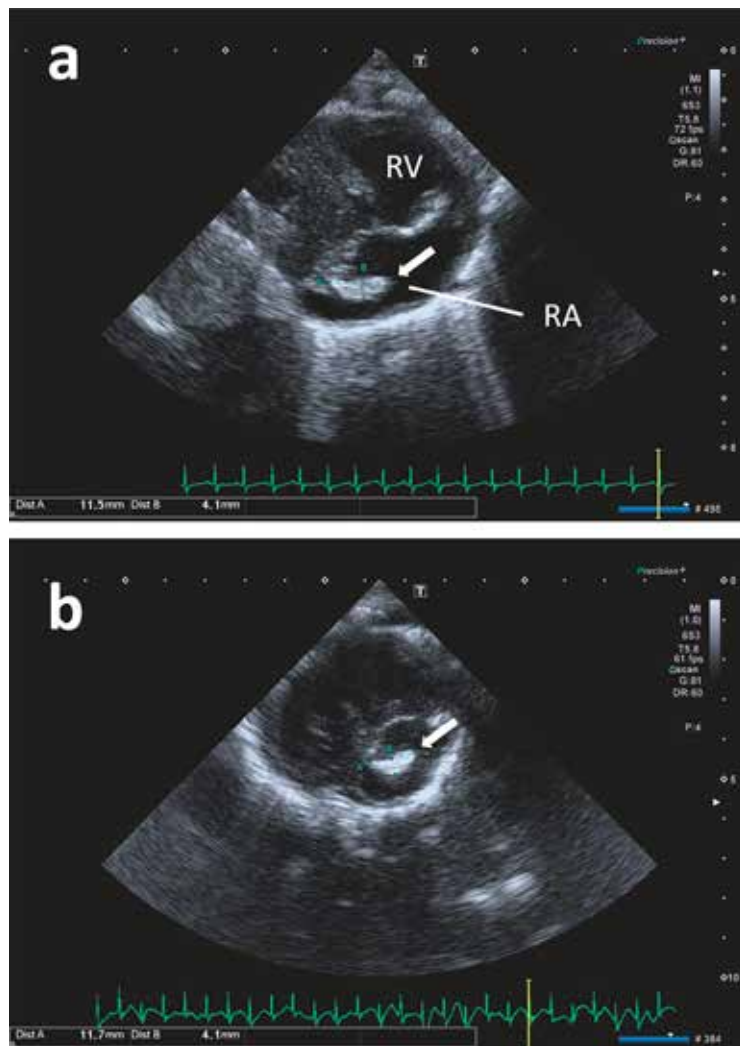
a) Echocardiography of our infant patient diagnosed with infectious endocarditis at 14 days of age. Vegetation with an associated stalk (white arrow) was observed on the right atrial wall around the posterior leaflet of the tricuspid valve annulus, measuring 11.5 × 4.5 mm. RV, right ventricle; RA, right atrium b) Echocardiography after the completion of antibiotic treatment at 54 days of age. Despite six weeks of treatment with vancomycin, the vegetation (white arrow) showed no significant change in size.
